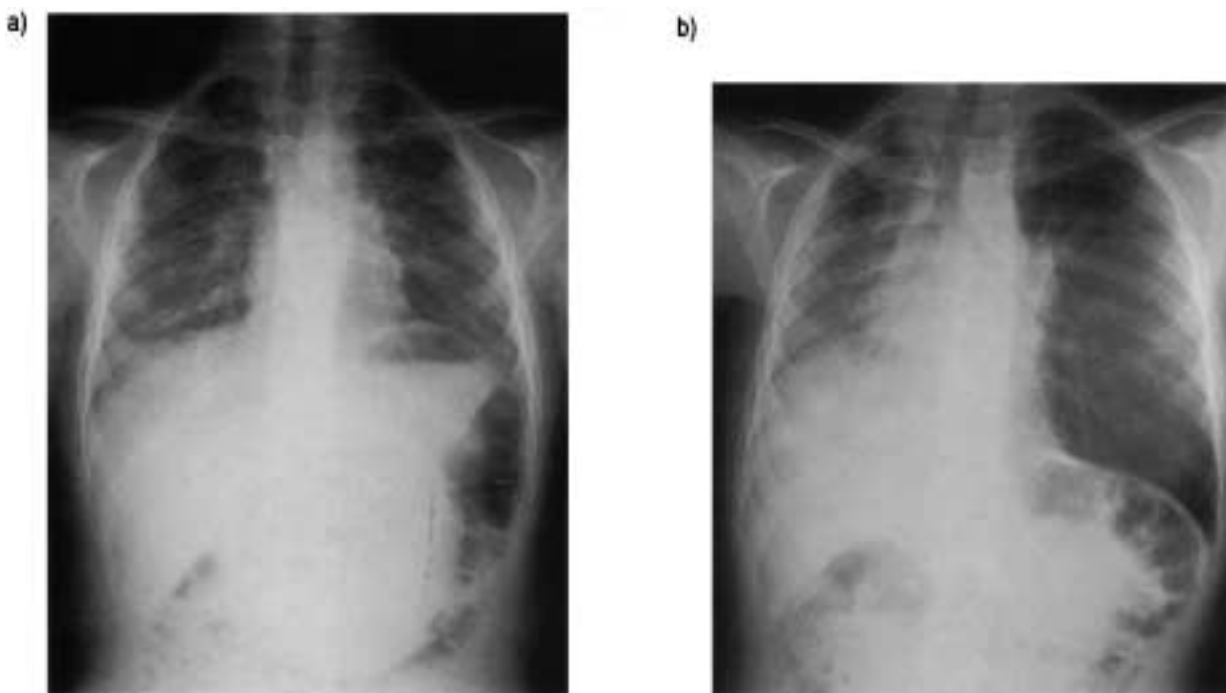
Chest radiographs from the patient: a) before and b) 4 months after left-sided lung lobe transplantation.
